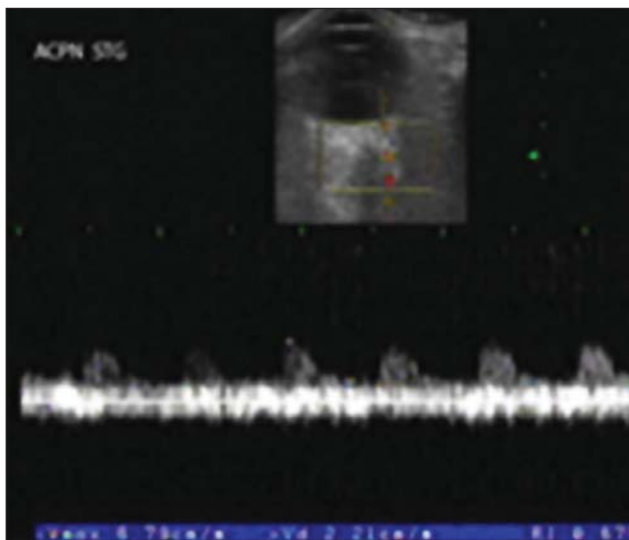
a, b. Patient MM-Spectral Doppler analysis of posterior ciliary arteries (PCA).
